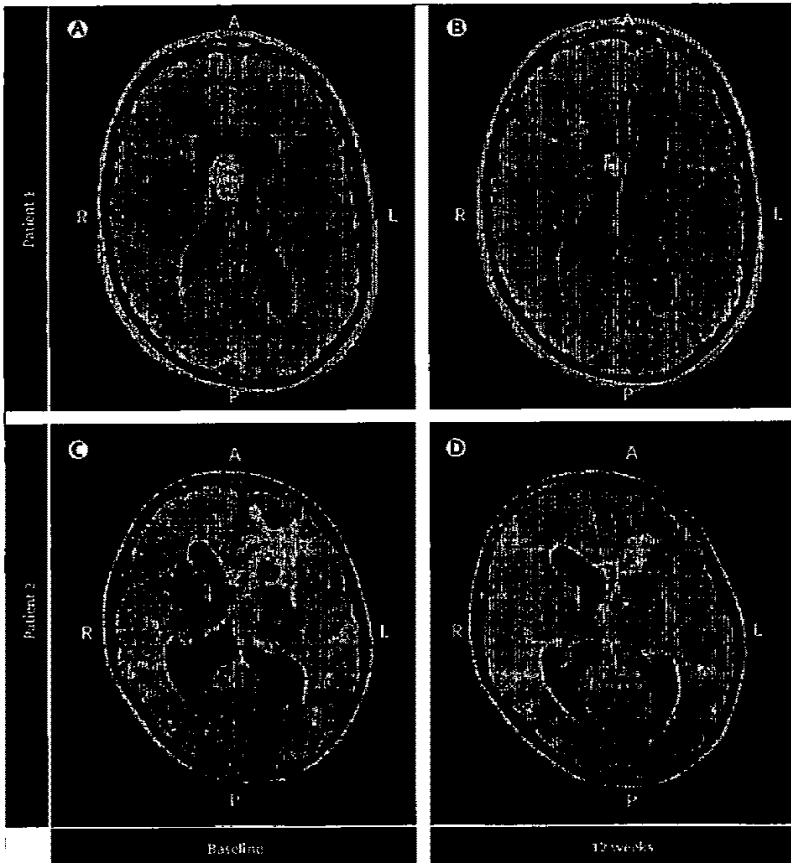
Contrast-enhanced axial fluid attenuated inversion recovery MRI of subependymal giant cell astrocytomas in two patients before (A, C) and after 12 weeks of everolimus (B, D). Volume of subependymal giant cell astrocytomas was reduced in the two patients after 12 weeks of everolimus. Peritumoral oedema and white matter dysplasia were also reduced in patient 2, who had an unsuccessful resection for subependymal giant cell astrocytomas. Ventricular size was reduced overall in patient 2 despite an apparent increase in the right frontal horn due to resolution of the mass effect from the oedema. A=anterior. R=right. L=left. P=posterior.
